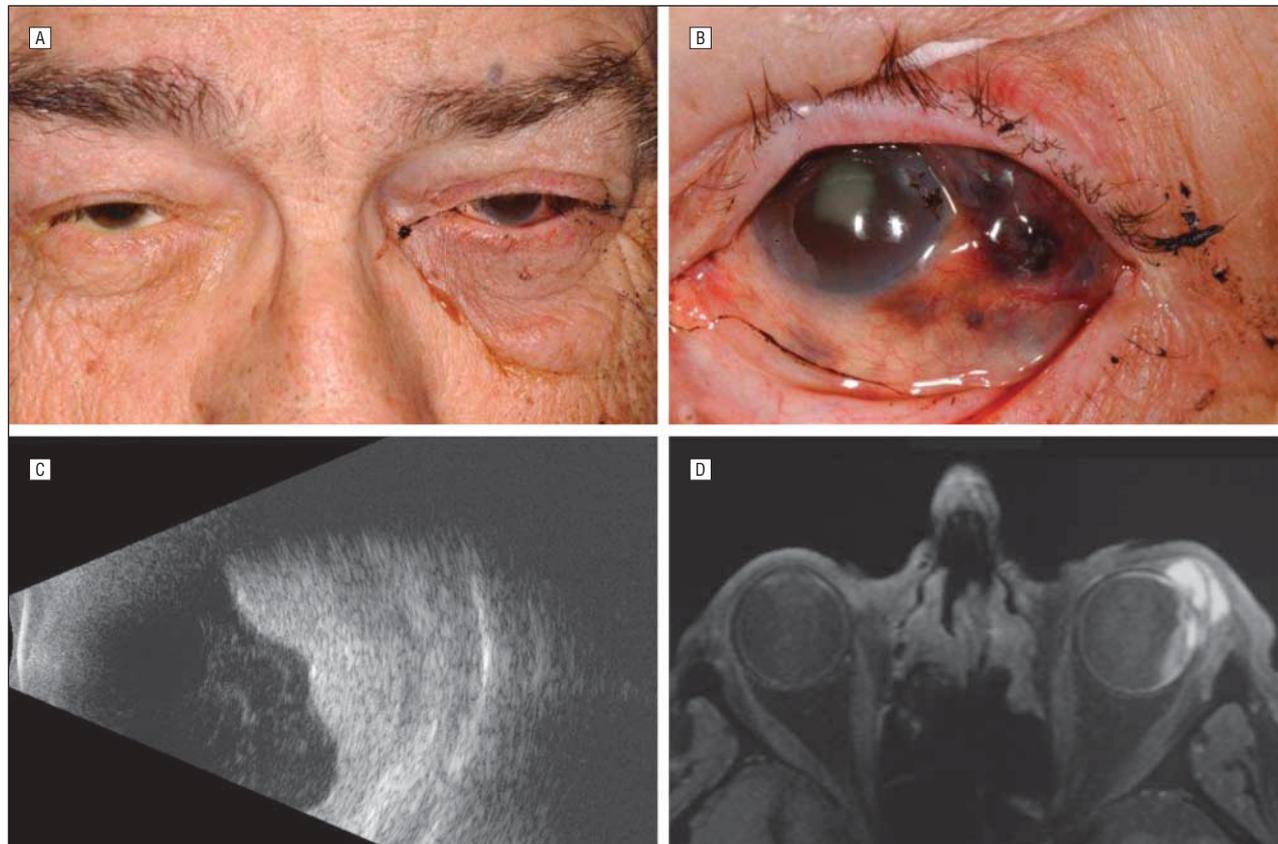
A 71-year-old man with black tears was found to have a necrotic, invasive uveal melanoma. A, Black, pigmented debris was noted on the left lower eyelid and cheek. B, Episcleral melanocytosis inferonasally and massive extraocular extension of the uveal melanoma temporally. Note the black mucus lining the inferior fornix and dried on the upper eyelid and cilia. C, B-scan ultrasonography showed an echodense intraocular mass with a slightly more lucent base. D, Magnetic resonance imaging revealed an intraocular mass with an epibulbar and orbital component.
